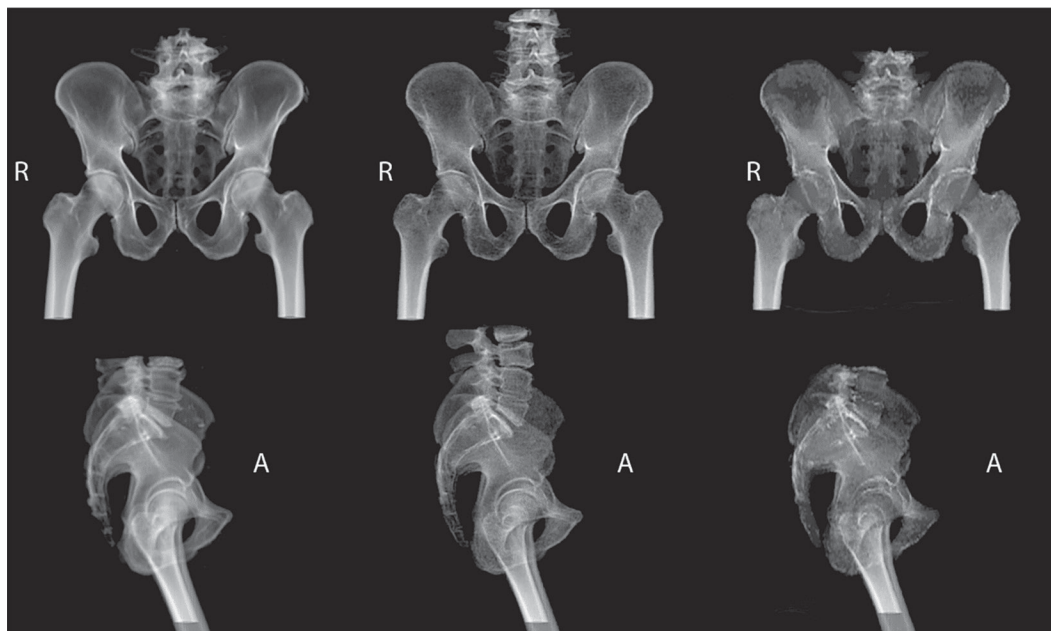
Example DRR images from Eclipse treatment planning system using bone rendering (HU values less than 100 and above 1000 omitted). CT (left), sCTc with continuous HU values (middle), and sCTb with discrete HU values, (right) (DRR: digitally reconstructed radiograph, HU: Hounsfield unit, CT: computed tomography, sCT: synthetic computed tomography, R: right, A: anterior).
